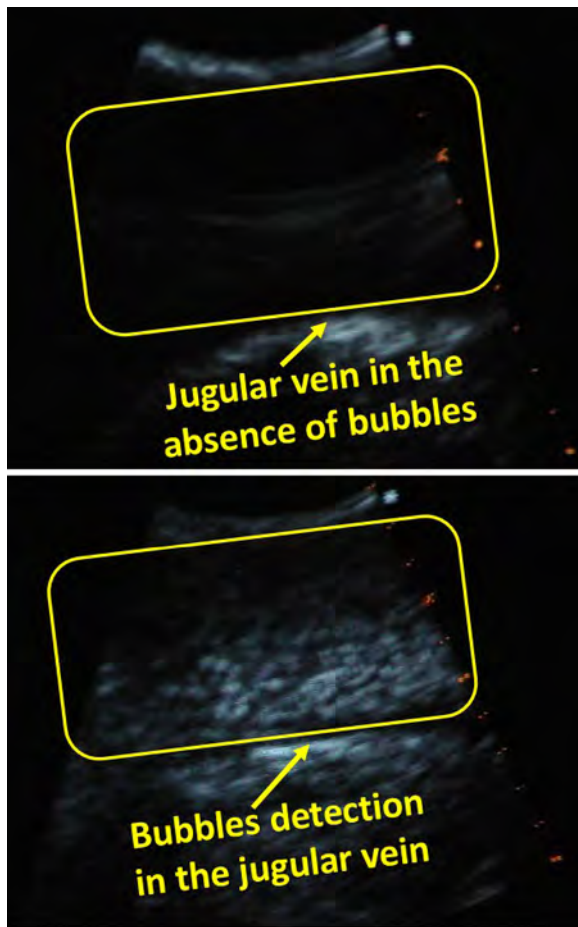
Detection of bubbles $30 \pm 10 \mu\text{m}$ inside the jugular vein by means of ultrasound measurements.
